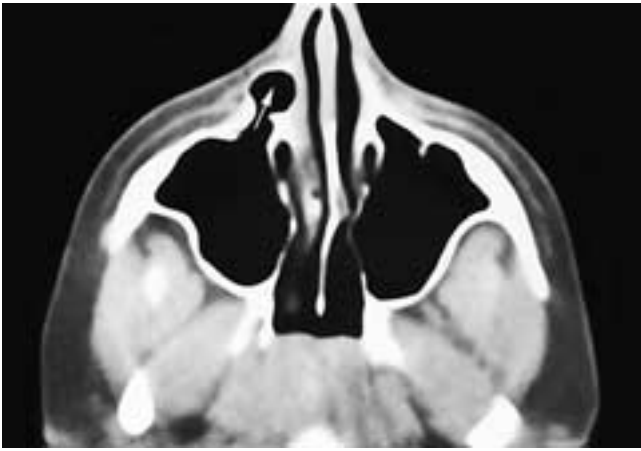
Axial CT scan shows a focal anterior enlargement of the right maxillary sinus (*arrow*) that has thinned the sinus wall and caused some cheek fullness. This patient had a pneumocele.
